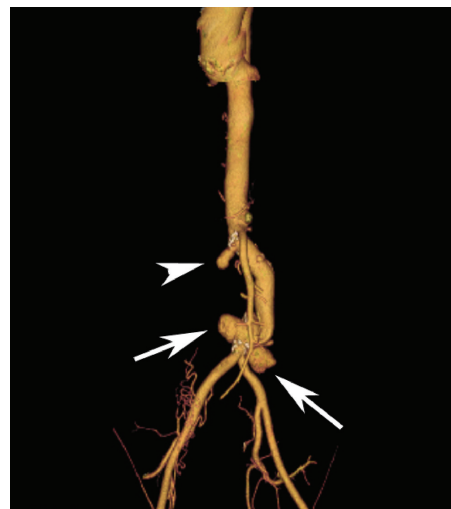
Contrast enhanced CT of aorta with 3D reconstruction show saccular aneurysms at lower abdominal aorta, just above aortic bifurcation (arrow), and another saccular aneurysm in the right side of abdominal aorta at juxtarenal position (arrow head). There is severe stenosis of bilateral main renal arteries (not show in image).
